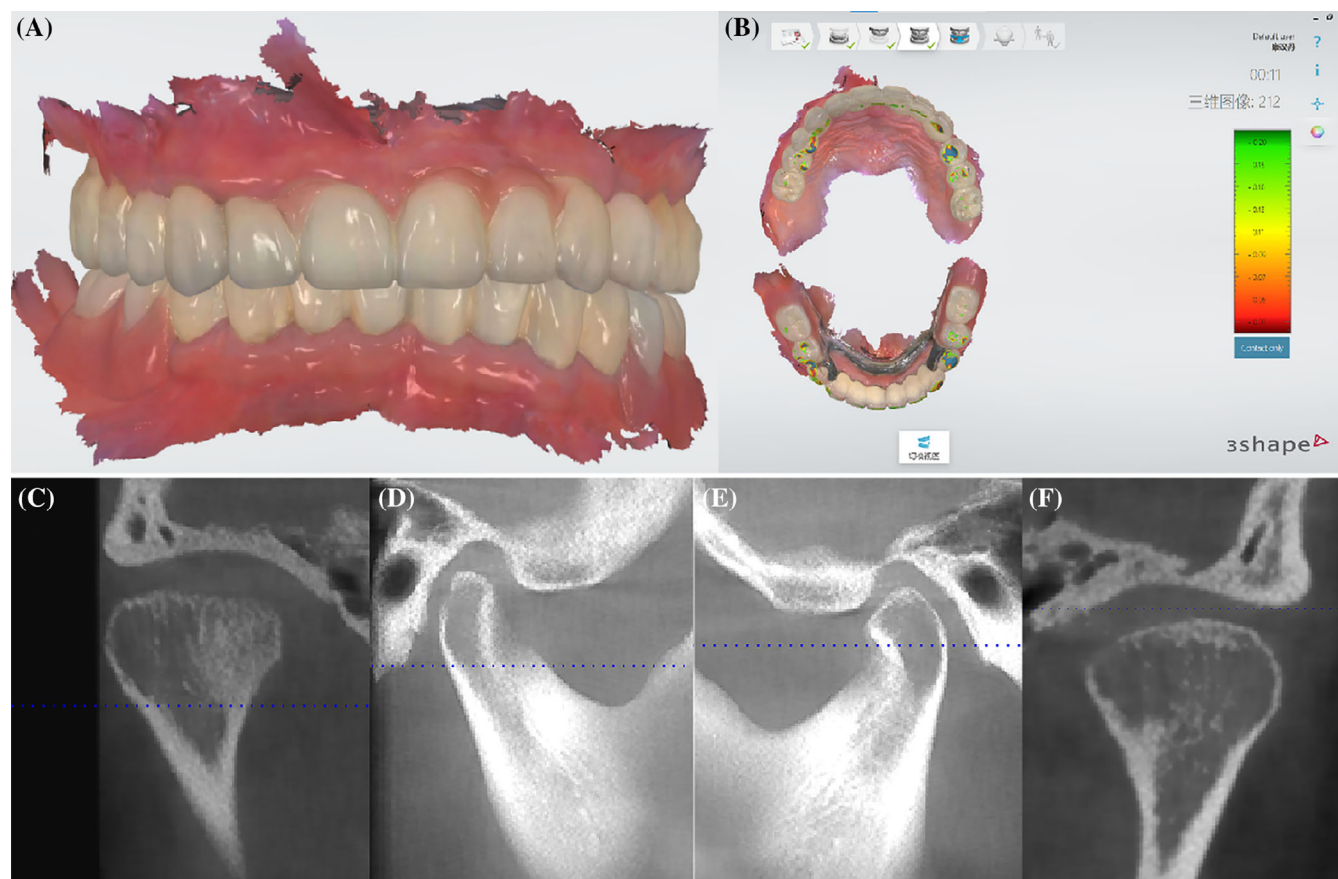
The auxiliary examination results after permanent restoration, including intraoral scanning to assess the occlusal relationship of the maxillary and mandibular arches and cone beam CT to assess the position of the bilateral condyles in temporomandibular joint. Intraoral scanning indicated that the patient's occlusal contacts were distributed throughout the dentition, with the bilateral molars adjusted for lighter occlusal contacts (A and B). Radiographic examination revealed that the condylar bone cortex remained intact bilaterally (C and F) and the condylar position was significantly closer to the anterior-superior position compared with before the treatment (D and E).
